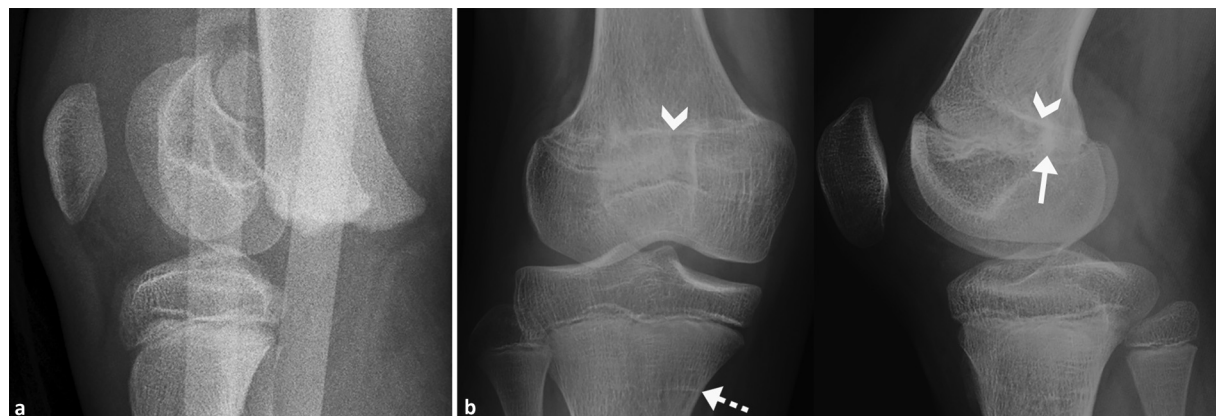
Growth disturbance with asymmetric growth. (a) Lateral radiograph shows a displaced Salter-Harris type II distal femur fracture in a 9-year-old boy, imaged with an external immobilizer in place. (b) Follow-up anteroposterior and lateral radiographs, obtained 2 years later, show posterior physeal closure (arrow), producing asymmetric growth across the distal femur and an angled growth arrest line (chevrons). Note the normal, almost completely reabsorbed faint growth arrest lines identified within the proximal tibial metaphysis (dashed arrow).
